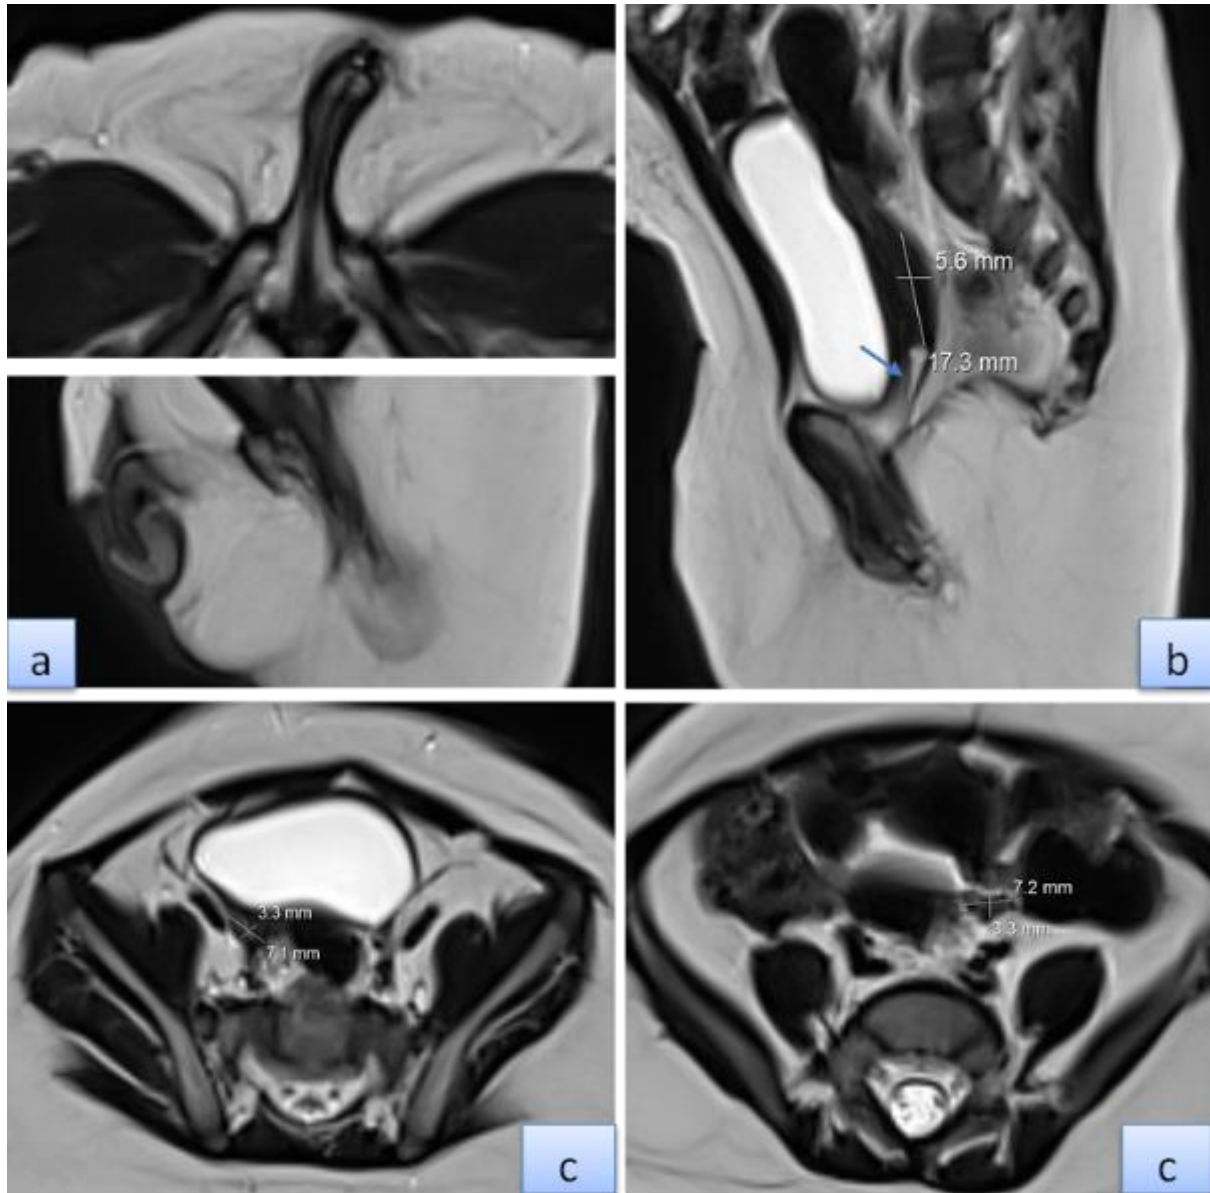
Pelvic MRI findings. (a) Subpubic median tubular structure with perineal subcutaneous fat hypertrophy and glans-like formation — clitoromegaly rather than a true penis. (b) Sagittal T2-weighted image showing the oblongue inter-vesico-rectal conduit (urogenital sinus, arrow) with T2-hyperintense fluid retention consistent with a vaginal component, and the small median uterus (arrowhead, 17.3 × 5.6 mm, endometrium 1.5 mm). (c) Axial T2-weighted image demonstrating two non-follicular latero-uterine structures at the ovarian fosses (arrows) — 7 × 3 mm right, 7.2 × 3.3 mm left — consistent with bilateral hypoplastic ovaries. Absence of scrotal tunics, epididymo-testicular complexes, and spermatic cords is noted throughout.
